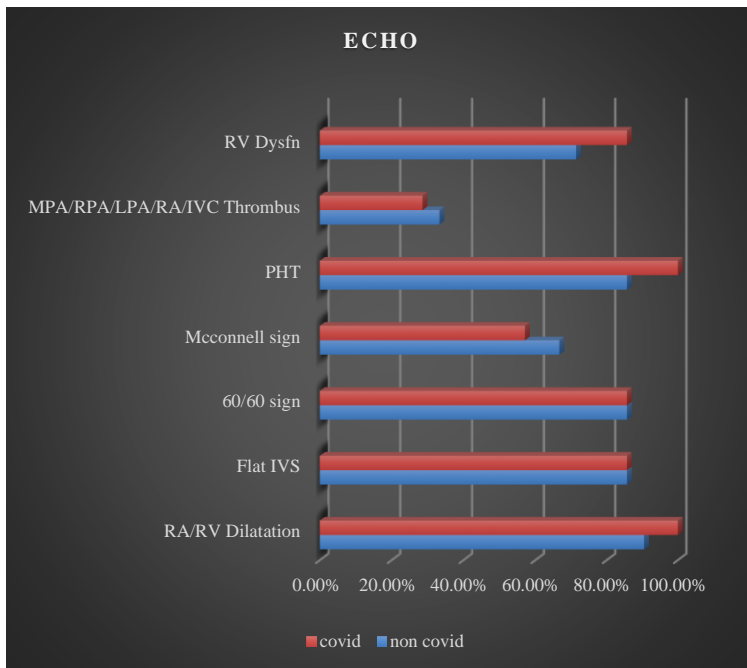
Echocardiographic manifestations in pulmonary embolism patients
